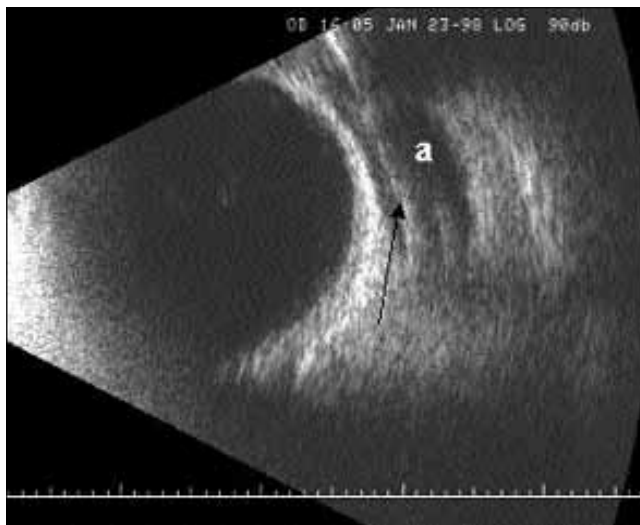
Filtration area viewed ultrasonically to check its functioning: filtration bleb (a), reflection at implant (arrow).
